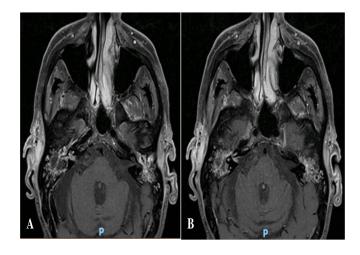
(A and B): MRI after gadolinium injection, where an increased sign of the right inner ear and the facial and vestibulocochlear nerves at the inner auditory canal is evident, suggesting labyrinthitis and neuritis.
